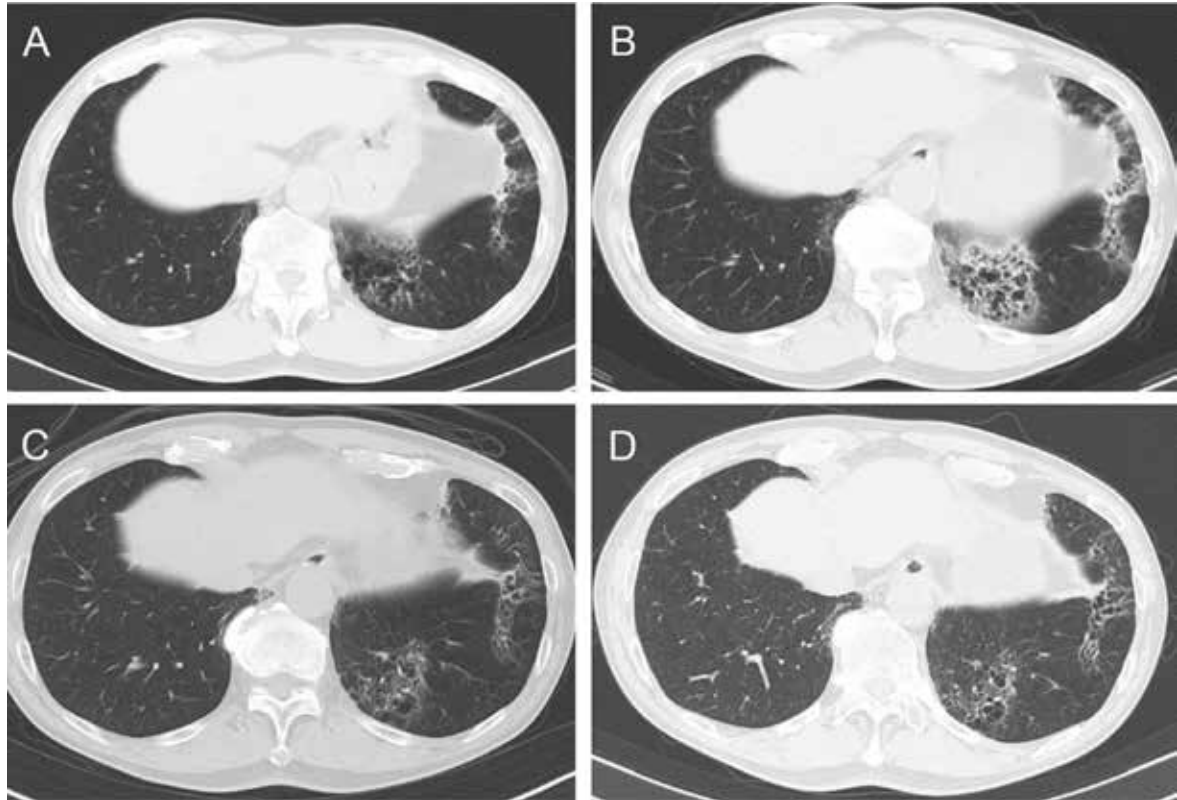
Chest computed tomography findings at the first visit for hemoptysis (A), 3 years after the initial symptoms (B), directly after completing antibiotic treatment (C), and 1 1/2 years after completing treatment (D).
